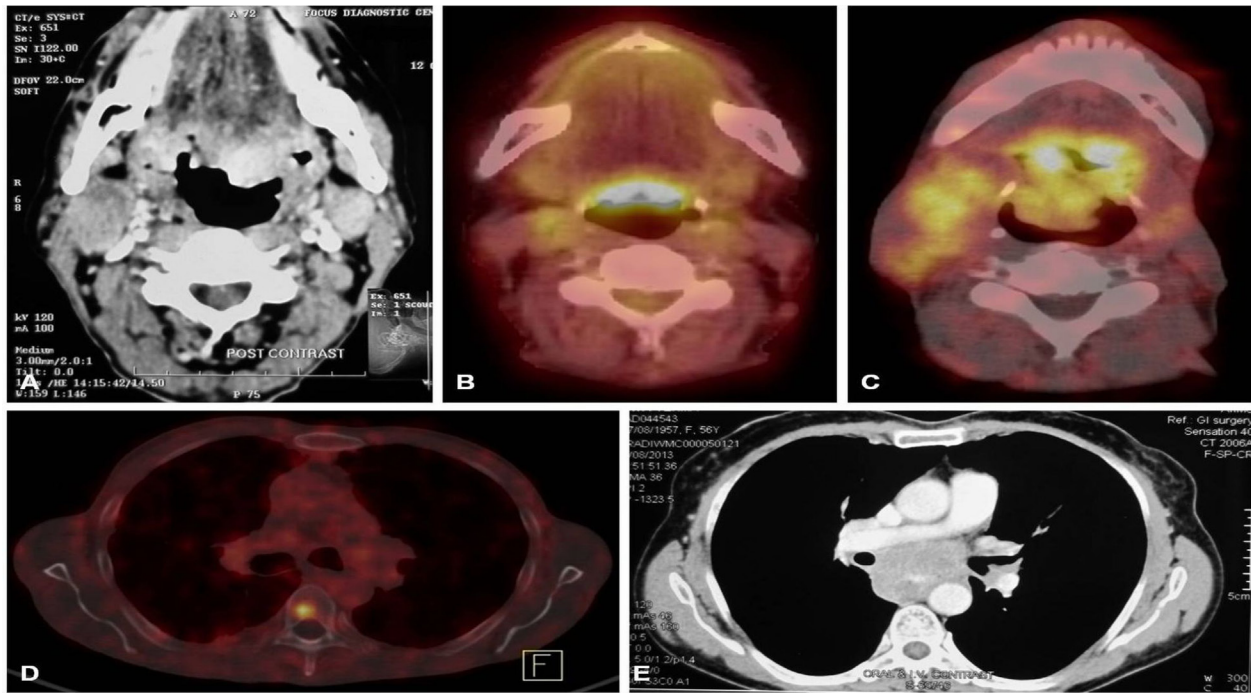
Axial Images of (A) CECT neck shows enhancing mass lesion involving base of tongue with bilateral cervical lymph nodes [case 1]; (B) fused 18F-FDG PET-CT shows soft-tissue thickening at base of tongue with uptake (SUVmax 6.74) [case 2]; (C) fused 18F-FDG PET-CT shows soft tissue mass involving bilateral valleculae with uptake (SUVmax 8.93), enlarged right cervical lymph nodes with uptake (SUVmax 10) [case 3]; (D) fused 68Ga-DOTANOC PET-CT (bone window) shows a small lytic lesion involving body of D6 vertebra with uptake (SUVmax 6.03) [case 3]; (E) CECT chest shows enhancing circumferential thickening of esophageal wall [case 4]
